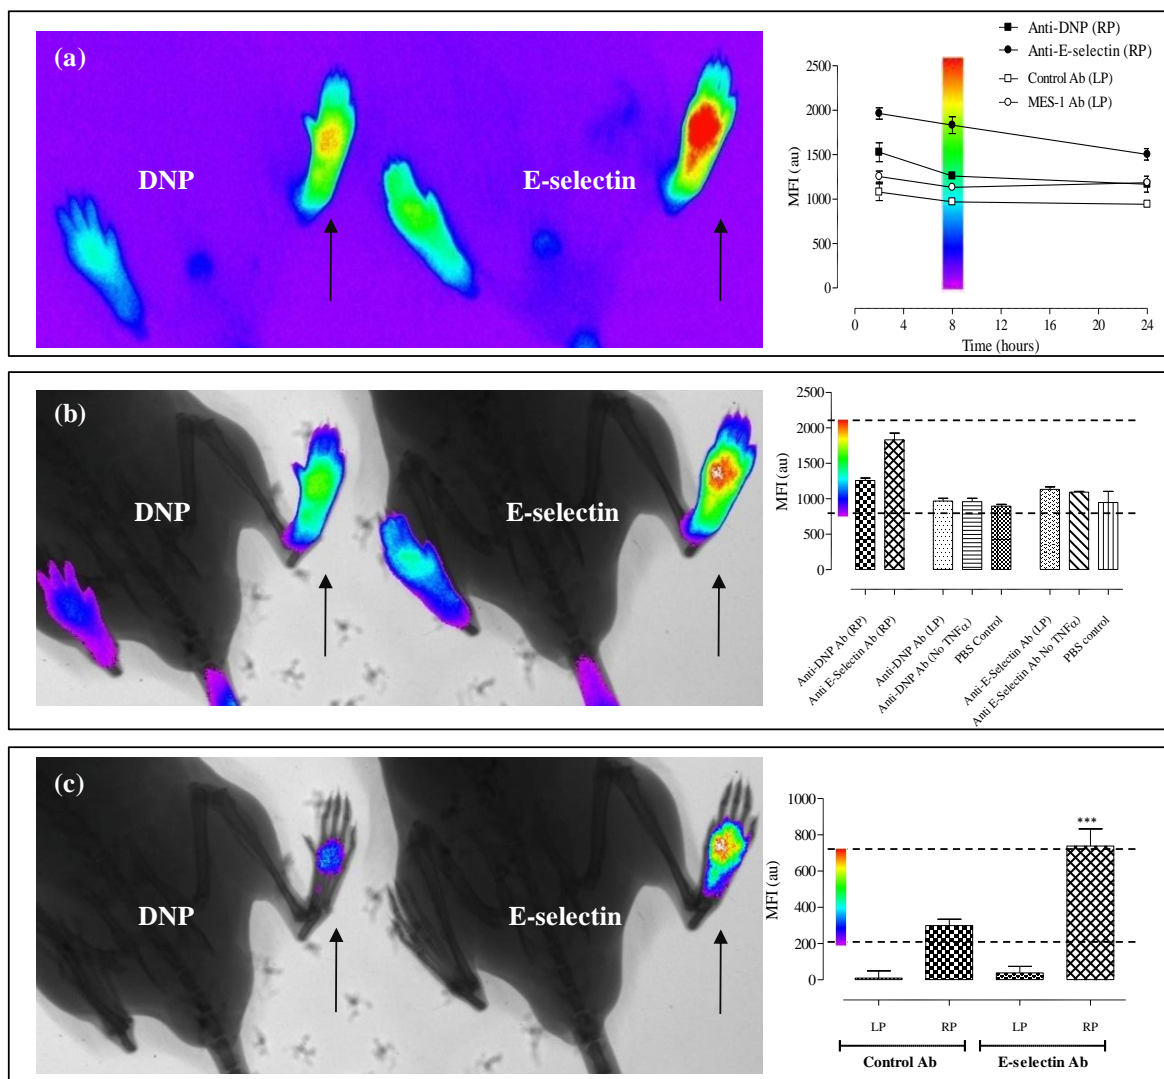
Specific anti-E-selectin targeted fluorescent signal co-registered with X-ray imaging
